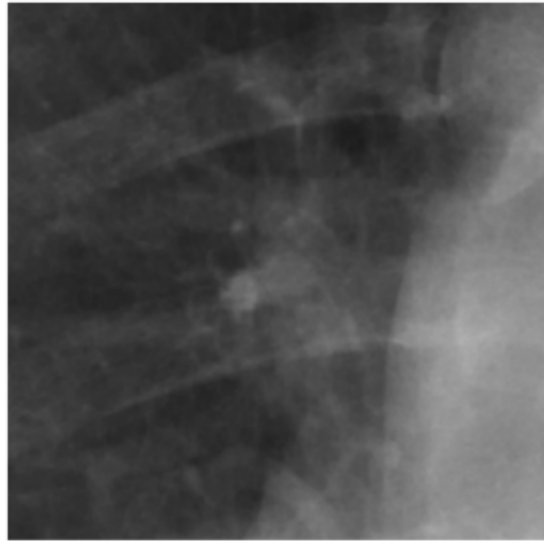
A detail in the lung of a patient chest X-ray image after blurring with $\sigma = 1$ pixel.
